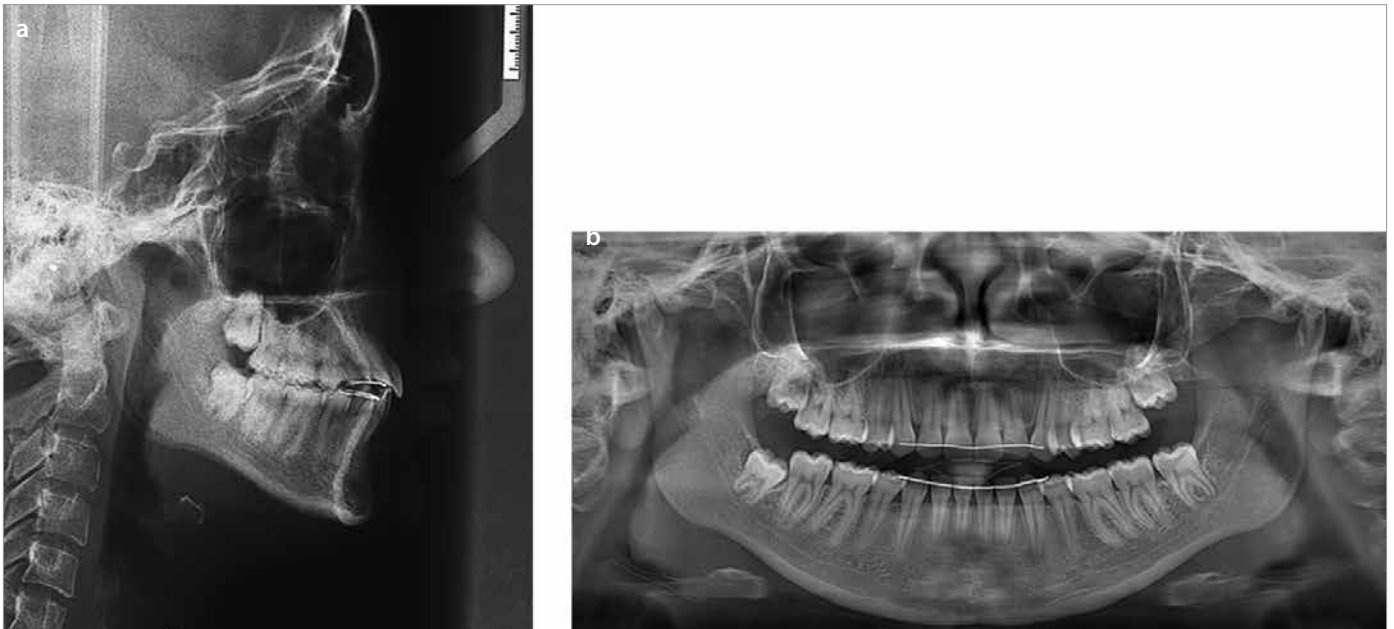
a, b. Lateral cephalometric radiograph 2 years after treatment (a); panoramic radiograph 2 years after treatment (b)
